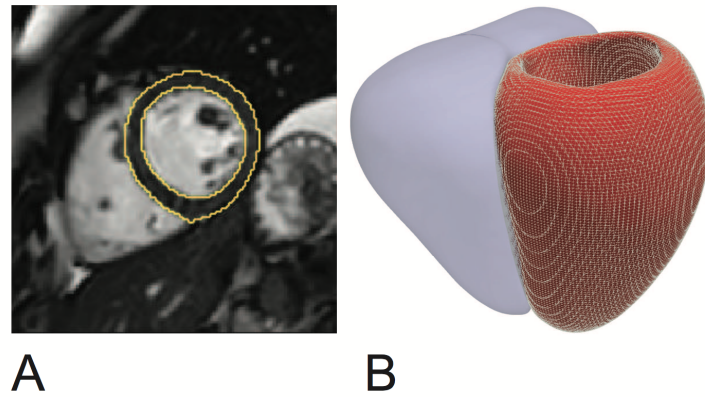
UK Digital Heart 3D high-resolution phenotypes derivation. (A) Short axis cardiac magnetic resonance image demonstrating automated segmentation of the endocardial and epicardial boundaries of the left ventricle. (B) The segmentation is used to construct a three dimensional mesh of the cardiac surfaces (left ventricle shown in red, right ventricle in blue) that is co-registered to a standard coordinate space. Phenotypic parameters, such as wall thickness, are then derived for each vertex in the model.
